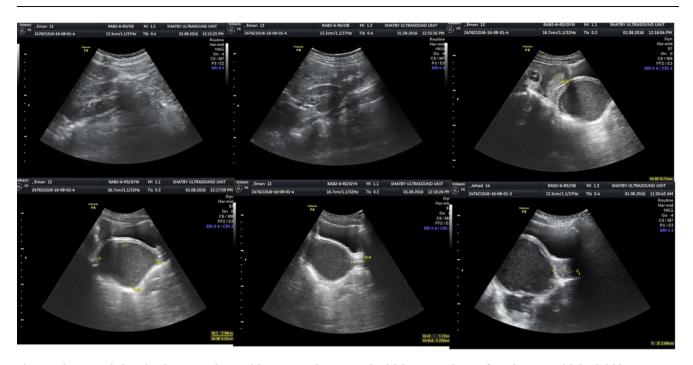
Ultrasound showing hematocolpus with septum about 1 cm in thickness and 5 cm from hymen with both kidneys seen
